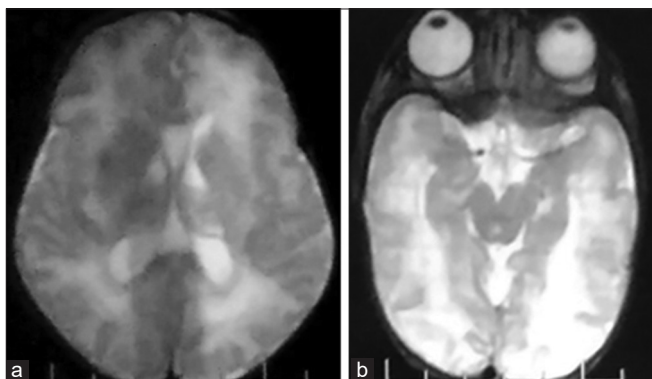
(a and b) T2 axial MRI brain showing hyperintense lesions with few subcortical cysts in bilateral parafalcine parietal lobes
